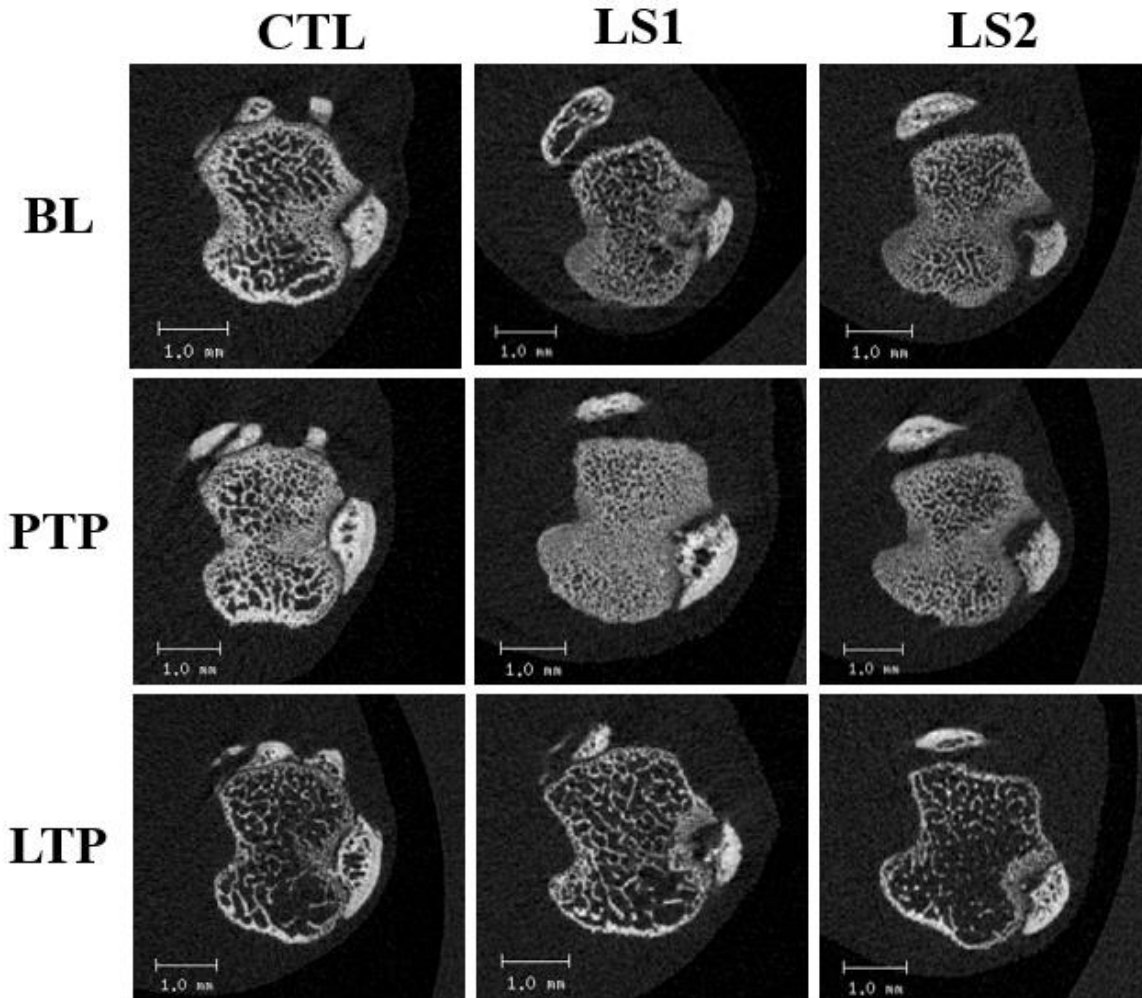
Representative right proximal tibiae cross-sections depicting approximate start location (10 slices from the distal tip of the posterior side of the proximal tibial epiphysis) of μ CT analyses of trabecular bone in the nulliparous (BL), postpartum (PTP), and lactating (LTP) females. CTL: Control, LS1: Longshanks 1, LS2: Longshanks 2. Scale bar set as 1 mm.
